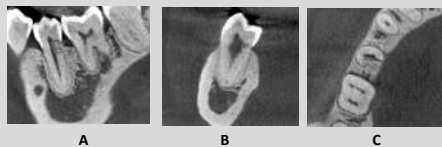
(A, B, C): Initial CBCT examination of the second right lower premolar. A-sagittal view; B-coronal view; C-axial view.
